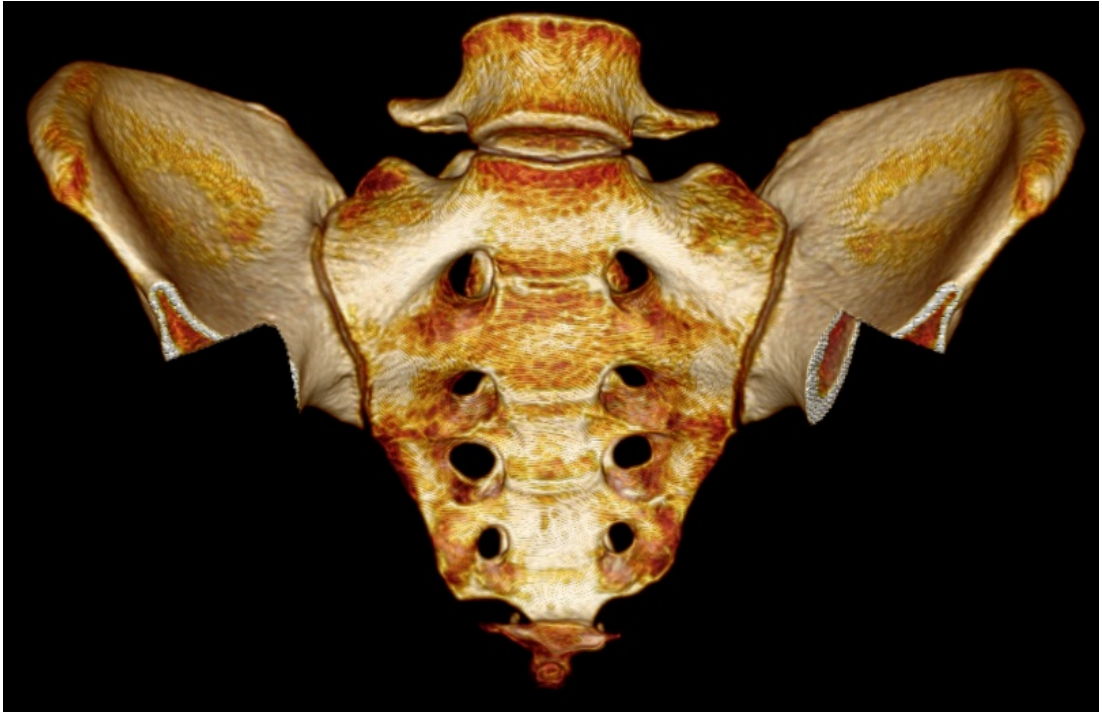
3D CT image of the pelvic girdle as created in OsiriX
